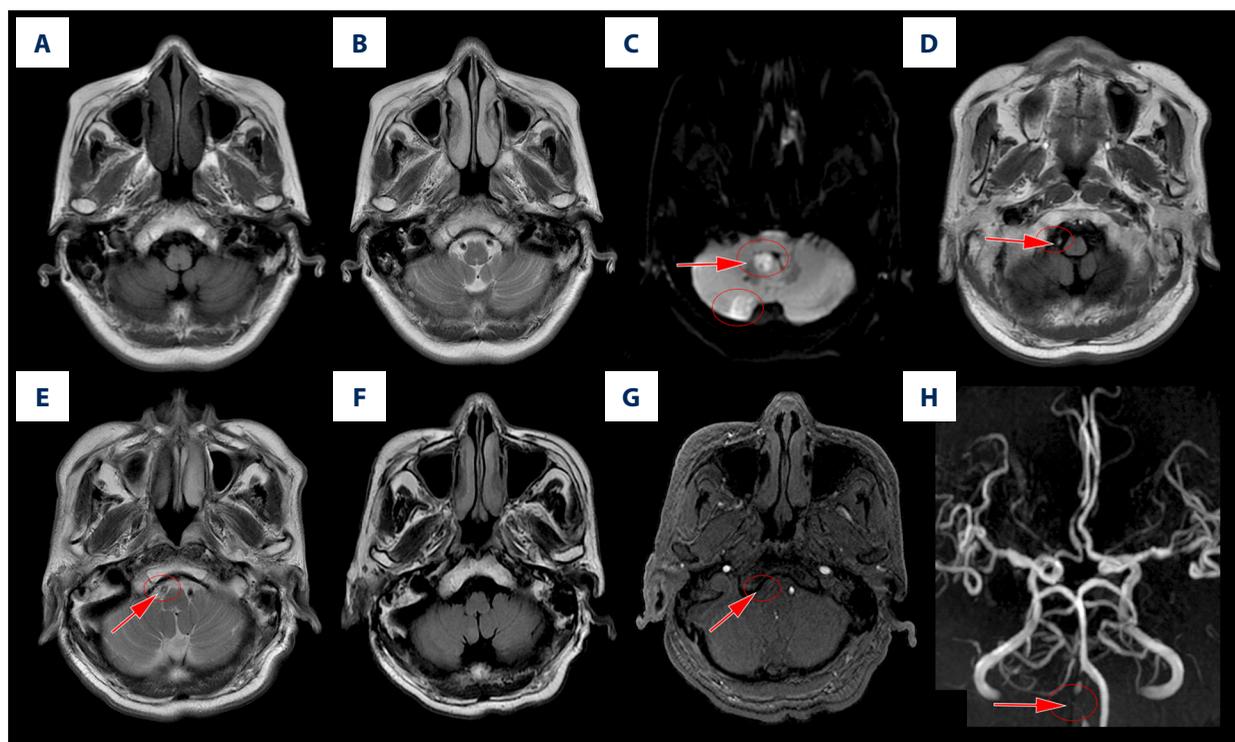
Example of HEVs in a PPCI patient who had the vertebral artery occlusion and the corresponding multiple cerebellum infarctions. This patient was hospitalized with dizziness and unstable walking. He suddenly began to progress on the seventh day of admission with the symptoms of dizziness, diplopia, and weakness of the right upper and lower limb. (A, B) MRI showed that the right vertebral artery had normal lumen, and flow void phenomenon existed on MRI T1 and T2 on the first day of admission. (C) DWI showed the right cerebellar hemisphere and tonsil infarction (arrow). (D, E) T1 and T2 showed that the blood flow void phenomenon of the right vertebral artery disappeared and HEVs were detected at the seventh day after admission (arrow). (F) FLAIR was normal. (G) The blood flow phenomenon of the right vertebral artery disappeared on 3D-TOF compared with the left side (arrow). (H) MRA indicated the possibility of right vertebral artery occlusion (arrow).
